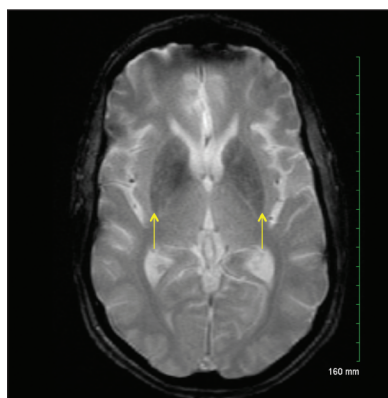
Gradient-echo magnetic resonance imaging scan of the brain in case 1, showing diffuse, somewhat increased mineralization seen as low signal intensity in the basal ganglia with bilateral involvement of the putamen (arrows) and caudate nucleus. Even lower signal intensity of the medial globus pallidus is a physiological finding.
